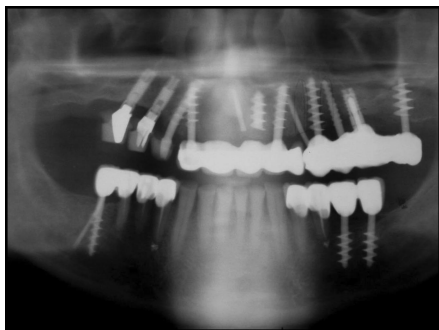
Panoramic x-ray of the screw-shaped implants.
